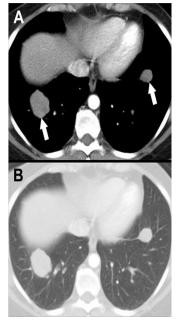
Contrast-enhanced chest Computed Tomography (CECT) sections with mediastinal and lung parenchyma windows, respectively, showing in anterior-basal segment of the inferior pulmonary lobes two, well-circumscribed lesions (arrows in A), with a maximum diameter of 3.5cm, and 2cm, respectively, mean density of 12-18 Hounsfield Units (HU) and homogeneous contrast enhancement.
